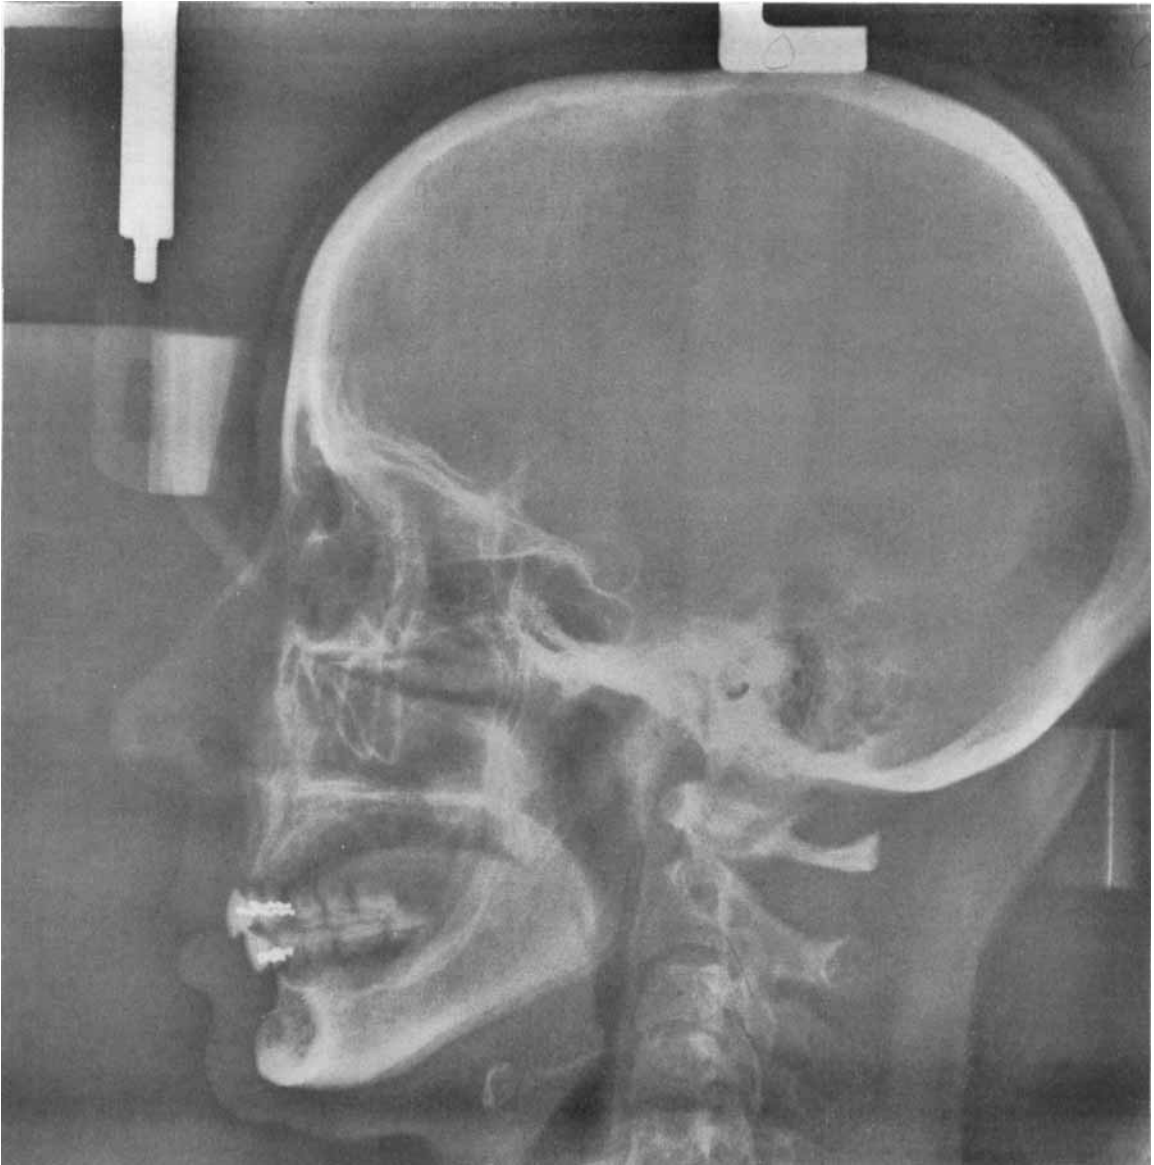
b. Profile radiograph of the same subject (Fig. 26 a) in occlusal position after 7 years of denture wear.
